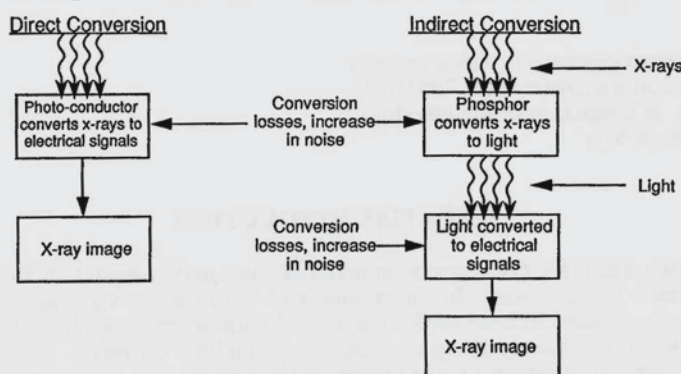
Comparison of direct and indirect energy conversion steps to obtain an x-ray image
